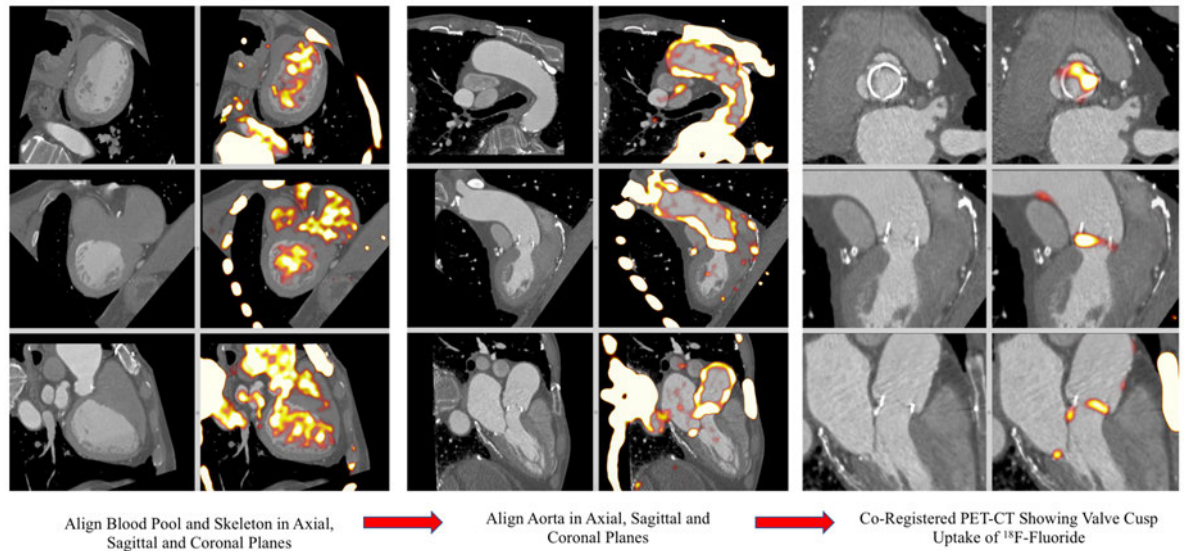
Careful alignment of the positron emission tomography (PET) activity in the cardiac blood pool with the contrast-enhanced computed tomography (CT) images is performed in 3 planes (left). This is possible because of the high ^{18}F -fluoride activity in the blood pool compared to the myocardium. Subsequently PET activity in the ascending aorta and aortic arch (center) is aligned with the CT and final refinement of co-registration is performed according to landmarks around the bioprosthetic aortic valve such as the coronary arteries and mitral valve annulus. Hybrid images are then re-orientated to provide en face images of the bioprosthetic valve with corresponding perpendicular long-axis images. Finally, the PET windowing is adjusted to the point below which blood pool activity in the aorta is visible to assess uptake in the valve leaflets.
